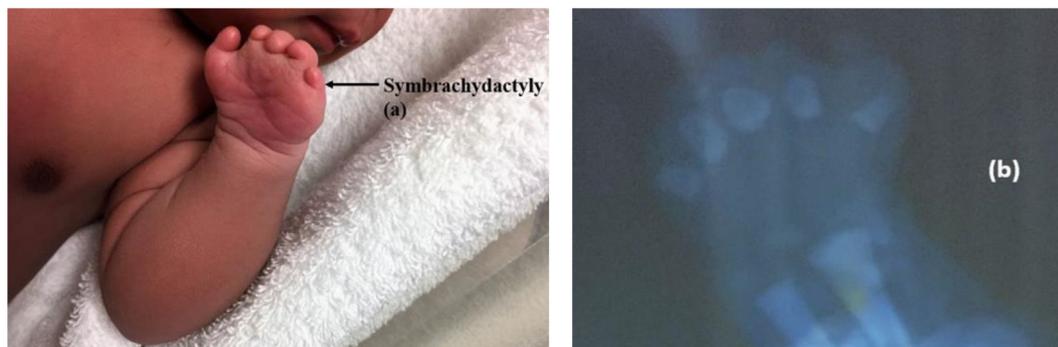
Symbrachydactyly (a) and X-ray (b) of the left hand at birth.
